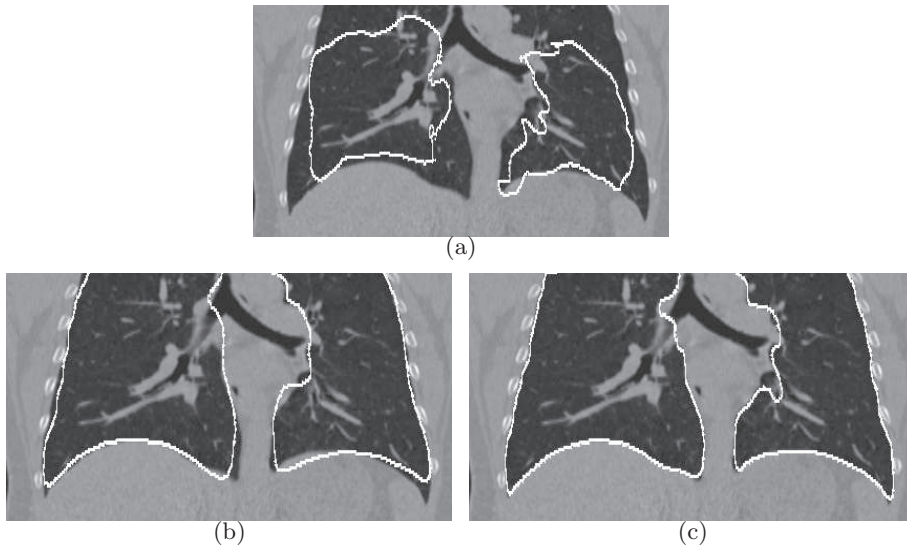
Segmentation of an incomplete lung CT data set; the top portion was not scanned. (a) Standard ASM. (b) Robust ASM. (c) Combination of robust ASM and optimal surface finding. Note that the standard and robust ASMs are not aware of the spatial extent of the data set, because of the clamping of gradient values to the boundary (Section 2.2.a). Surfaces outside of the data set were clipped after the segmentation process was completed.
